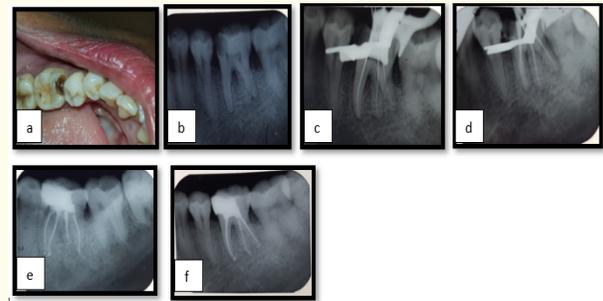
(a) Pre Operative occlusal view of 36. (b) Pre Operative radiographic view of 36. (c) Working Length Radiograph of 36. (d) Master Cone Radiograph of 36. (e&f) Postoperative Radiograph of 36.
